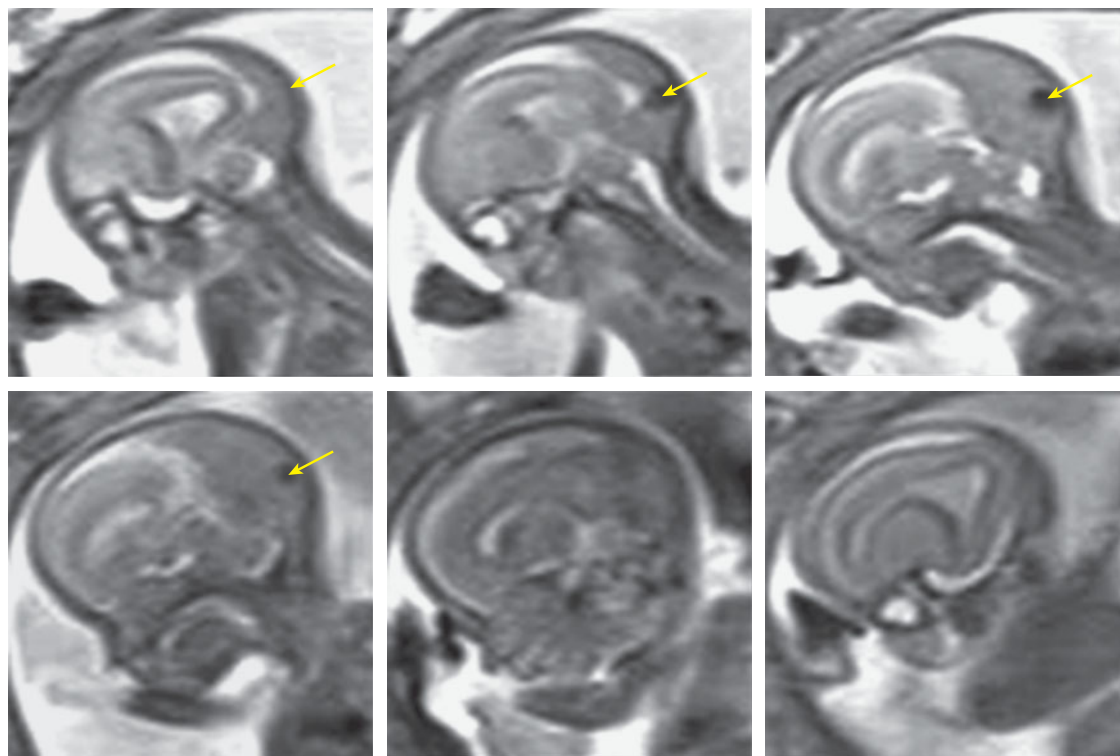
Serial sagittal MRI of the torcular thrombosis seen in Figures 10-12 to 10-15. (The arrow points to the thrombus.)
